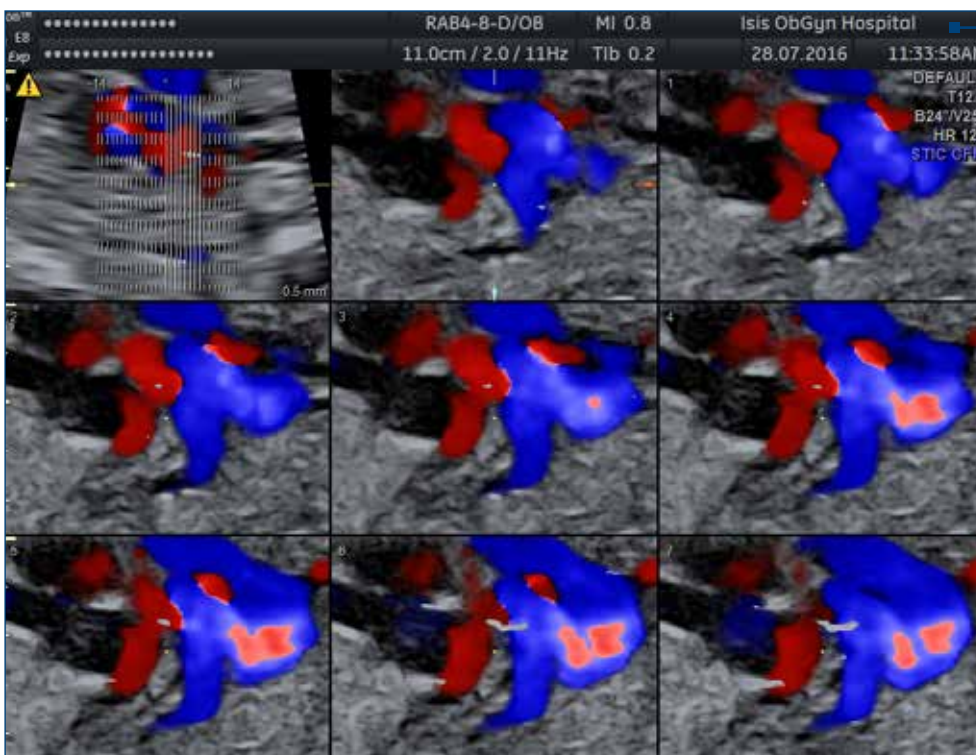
Ultrasonography showing the outflow track of the two great vessels with the parallel trajectory and no crossing between them, by the spatiotemporal image correlation (STIC) with tomographic ultrasound imaging (TUI)
